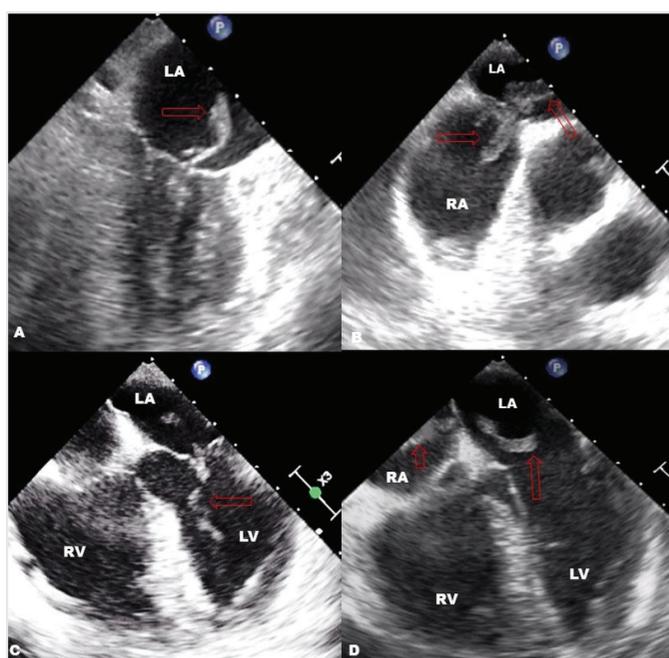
Transesophageal echocardiography demonstrating a large and long trapped thrombus image in the interatrial septum with an enlargement of the right ventricle and the atrium that extends from the mitral valve to the left ventricle (A-D)
